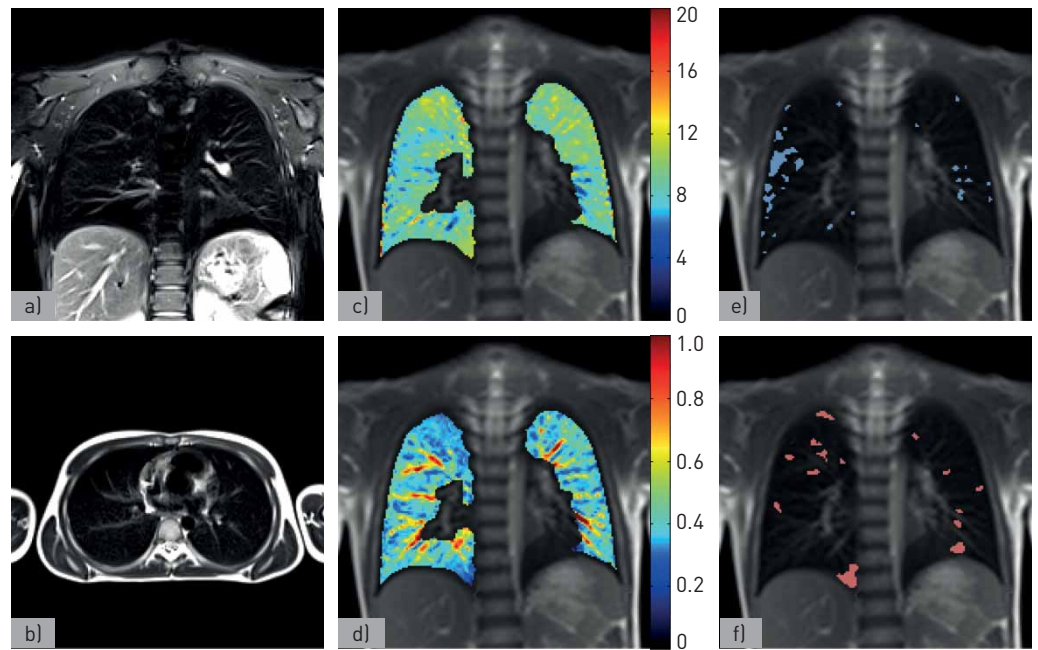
Example of a healthy child: a 7-year-old healthy boy. a) Coronal and b) axial 5-mm T2-weighted BLADE and HASTE (half-Fourier acquisition single-shot turbo spin-echo) images, respectively. Chest magnetic resonance imaging (MRI) was normal. c, d) Functional MRI shows fairly homogeneous distribution of c) fractional ventilation as well as d) relative perfusion. Small regions in both lungs were classified as hypoperfused as well as peripheral regions in the middle lobe of the right lung as hypoventilated. e, f) Masks overlaid on morphological images present e) fractional ventilation defects (5% of the slice area) and f) perfusion defects (4% of the slice area). Both lung clearance index (5.7 lung turnovers) and forced expiratory volume in 1 s ( $-0.30$  z-scores) were normal.
